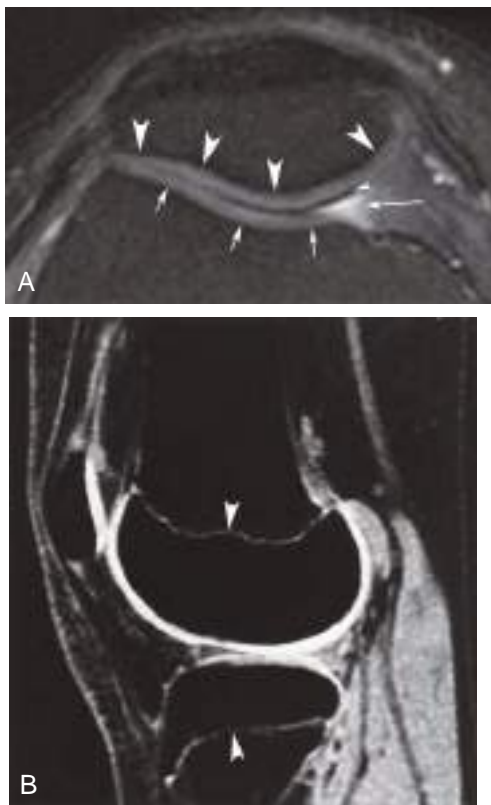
Normal articular cartilage. (A) Axial fat-suppressed T2-weighted fast spin-echo (echo time, 45 msec) MR image obtained through the patella shows patellar (*large arrowheads*) and femoral trochlea (*short arrows*) cartilage. Careful observation shows slightly higher signal intensity in the intermediate layer (due to lack of anisotropy in this layer). The dark line between the patellar and trochlear cartilage (*small arrowhead*) is due to susceptibility artifact. Contrast the overall intermediate signal intensity of the normal articular cartilage with the high signal intensity of joint fluid (*long arrow*). Cartilage defects are seen as high-signal regions. (B) Sagittal fat-suppressed three-dimensional spoiled gradient-echo MR image (repetition time, 60 msec; echo time, 5 msec; flip angle, 40 degrees) shows normal articular cartilage of the knee. Also note similar, normal signal of distal femoral and proximal tibial growth plates (*arrowheads*). Hyaline cartilage is bright on this imaging sequence. Cartilage defects are seen as low-signal regions.
